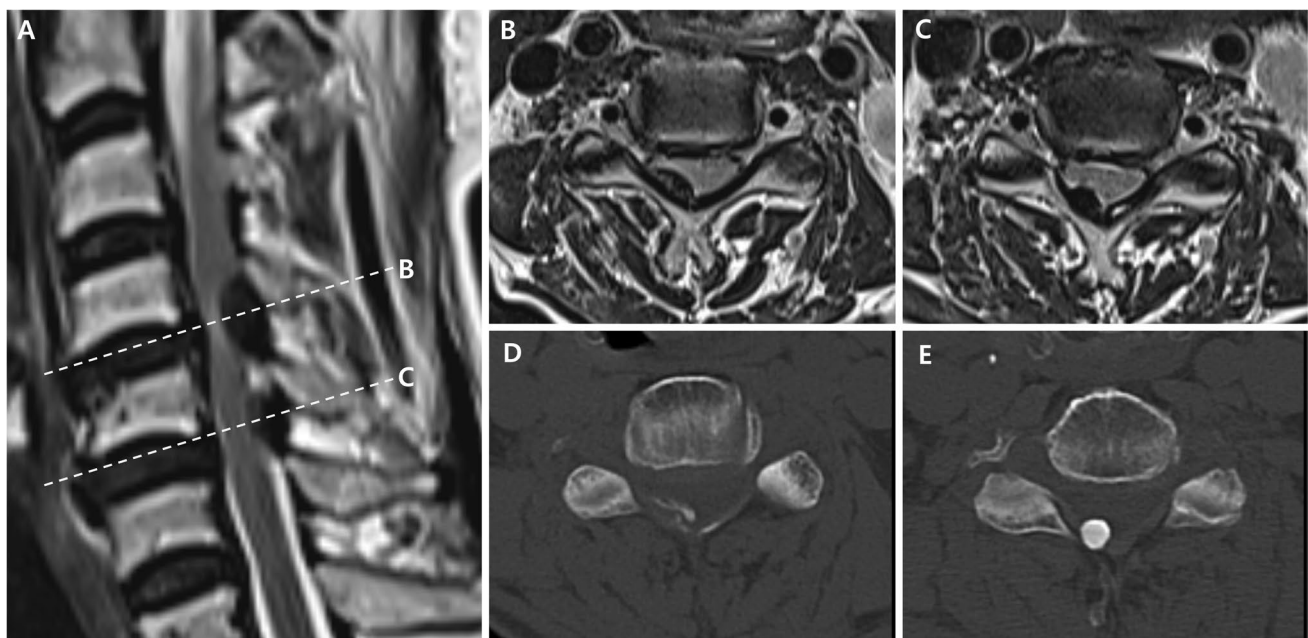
Pre-operative images of Case 1. A: Sagittal plane of MRI scan, indicating compressive myelopathy at C4-5 and C5-6 levels, with more severe cord signal change at C4-5. B: Axial plane of MRI scan at C4-5 level. C: Axial plane of MRI scan at C5-6 level. D: Axial
